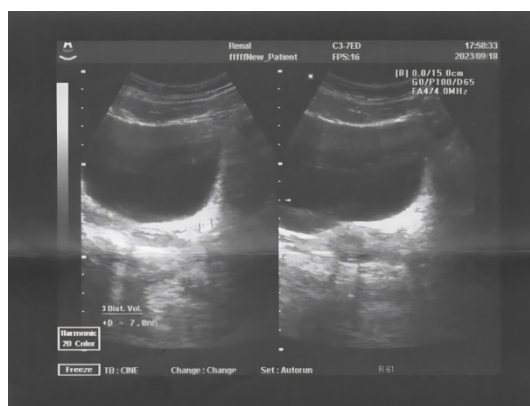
Patient G. Ultrasound of the bladder from September 20th, 2023. Hyperechoic formation in the lower third of the ureter on the left
